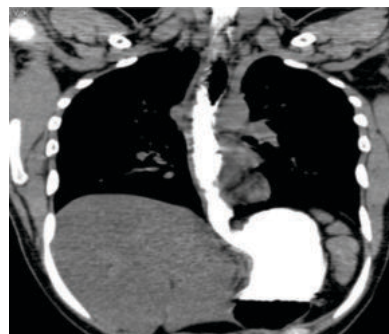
CT Chest With Oral Contrast Showing Diffuse Symmetrical Wall Thickening Of Entire Esophagus, But More Predominant In Distal Esophagus
